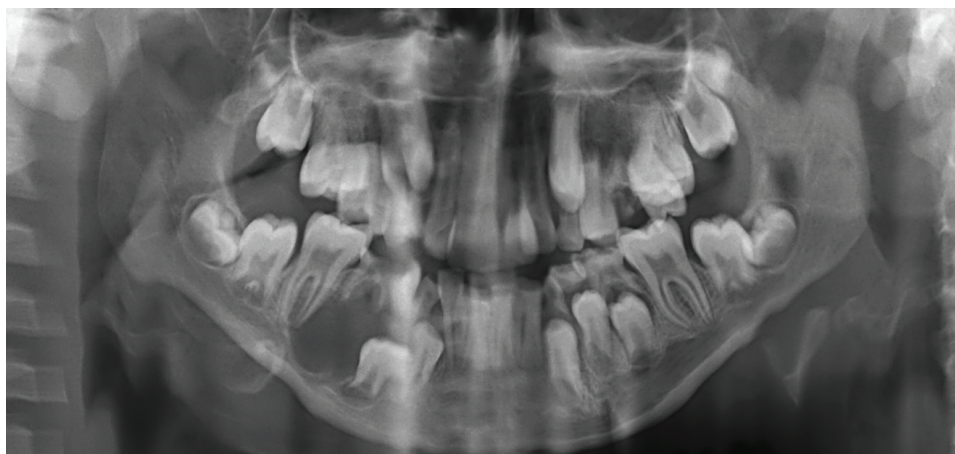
The panoramic radiograph obtained in this case depicts a grossly carious tooth 85 in association with a large lateral cystic lesion which is attached at the cemento-enamel junction of the impacted and displaced tooth 44. Generalised crowding of the remaining dentition is noted.
